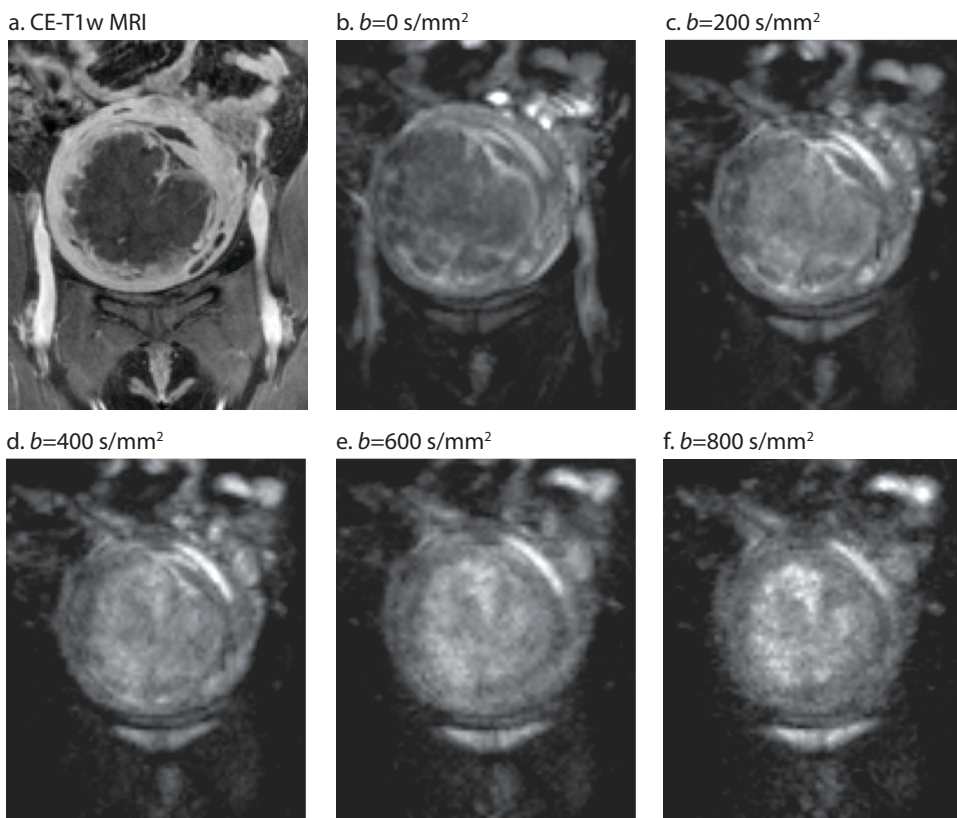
Contrast-enhanced T1-weighted MRI showing the non-perfused volume 1b-f. Post-treatment diffusion-weighted MRI acquired using different b -values, showing areas of increased signal intensity inside the treated fibroid. Note: images are scaled per b -value.
